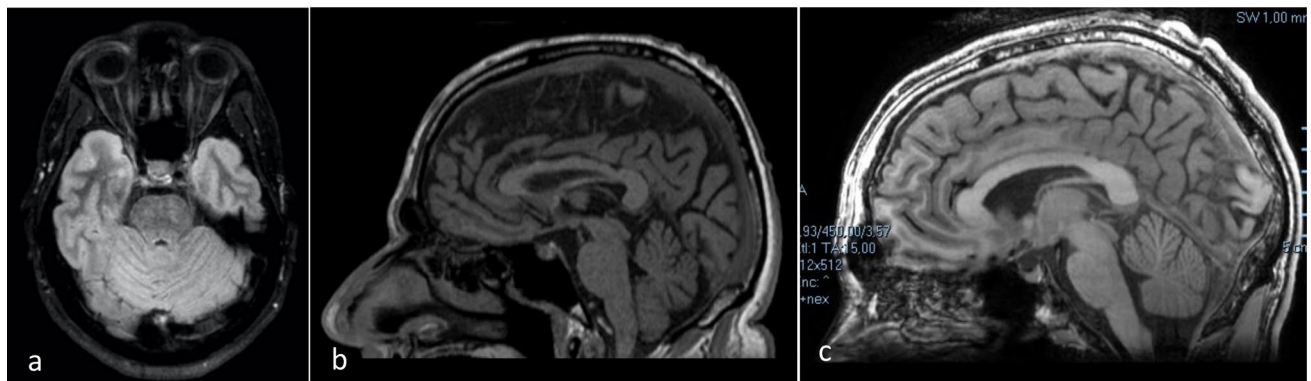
Cerebral MRI of patients with dominant *UCHL1*-related disease. a bilateral optic nerve atrophy without cerebellar atrophy (subject III.2, family 1); b very mild hemispheric cerebellar atrophy
